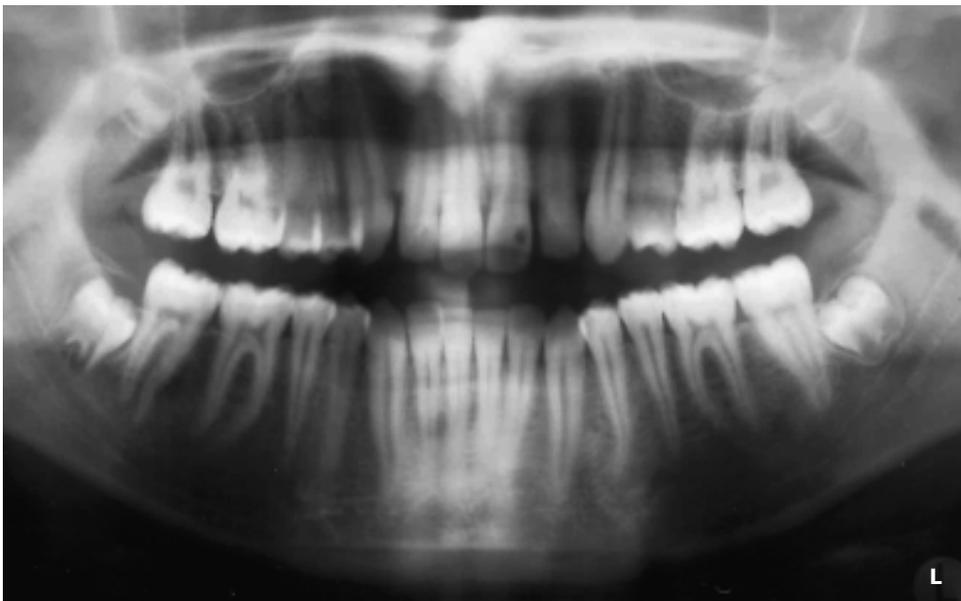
Interindividual differences in third molar development. Panoramic radiograph of boy 16 year old.
